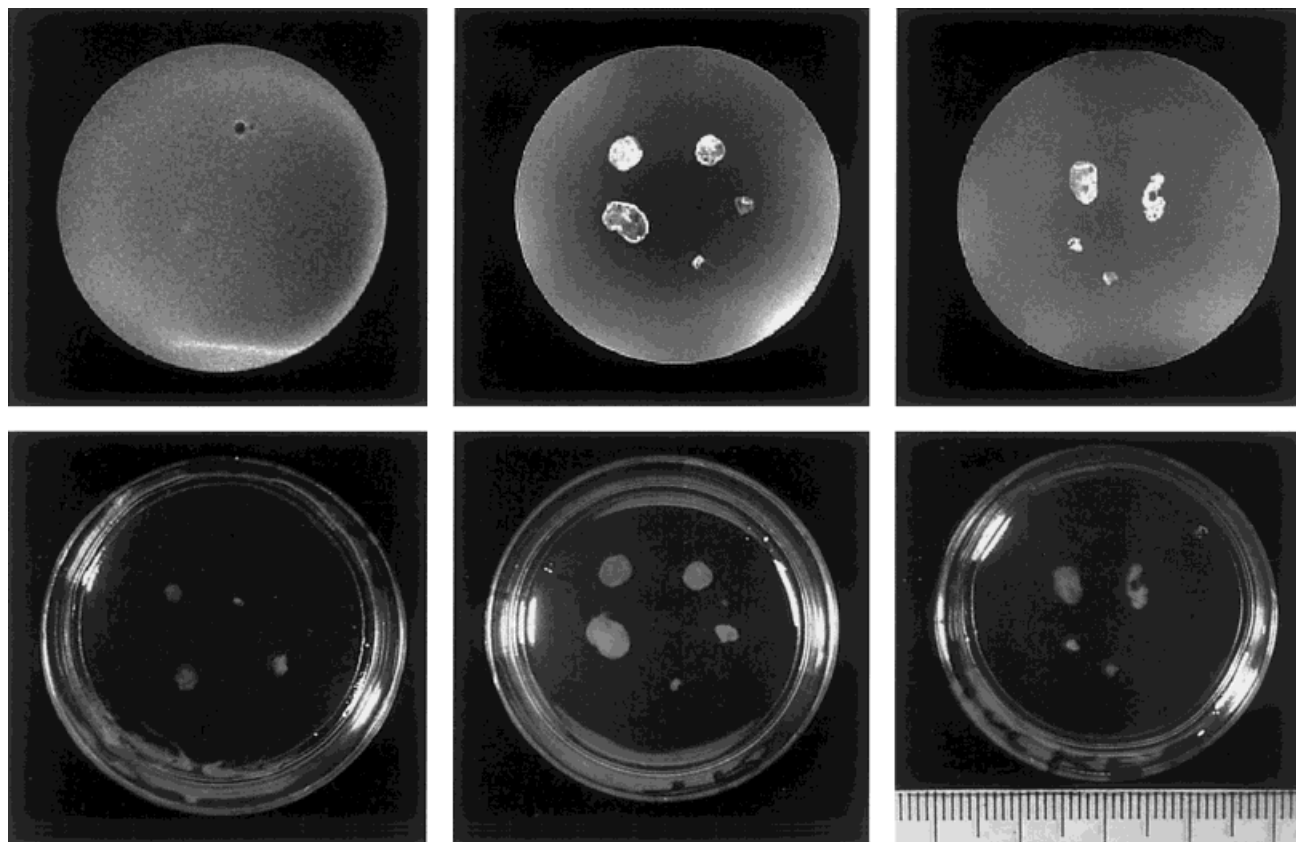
T_1 -weighted spin-echo images (upper panels) of clots embedded in agarose gel on a petri dish. Each small grid in the scalar bar represents 1 mm. Untreated clots (left) showed no contrast with agarose gel, while both treated (center) and partially blocked (right) clots showed excellent contrast. Direct comparison with the corresponding optical images (lower panels) indicates that MR images can also accurately delineate the morphology of the clots.
